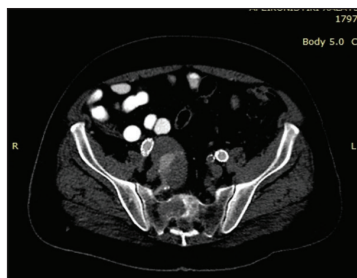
Arterial phase, axial CTA showing the aneurysmal sac and its partial filling with contrast media.
